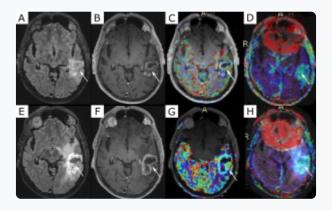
Top row: first MRI examination after temozolomide and radiation therapy. Bottom row: follow-up MRI after 3 months. Contrast-enhanced Fluid Attenuated Inversion Recovery (FLAIR) (A, E). Contrast-enhanced T1W (B, F). DSC PWI relative Cerebral Blood Volume (rCBV) (C, G). APT map (D, H). We can see tumor progression between the top and bottom row on conventional (FLAIR, T1W) images and on perfusion and APT imaging. Based on literature(17), APT signal was over the suggested thresholds for TP (>2,795%).
